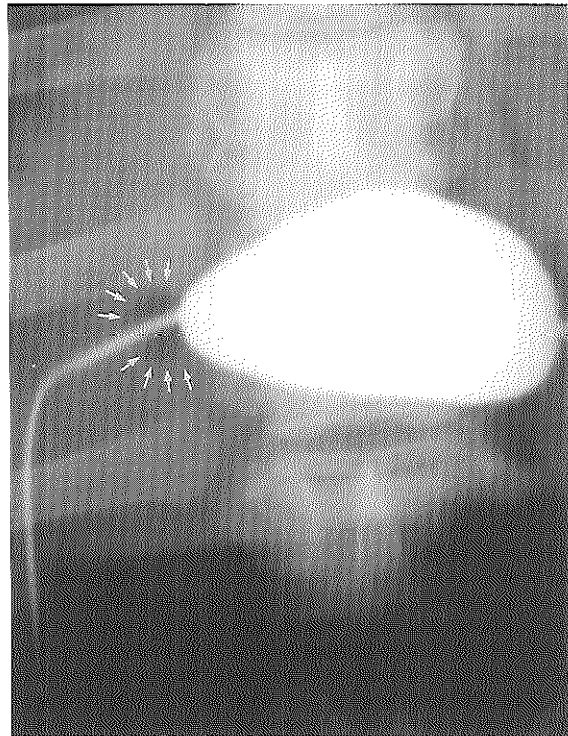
Radiograph of the abdomen after filling the gallbladder with contrast to control the position of the balloon (arrows). The cystic duct is completely occluded; there is no leakage of contrast in the bile duct.
